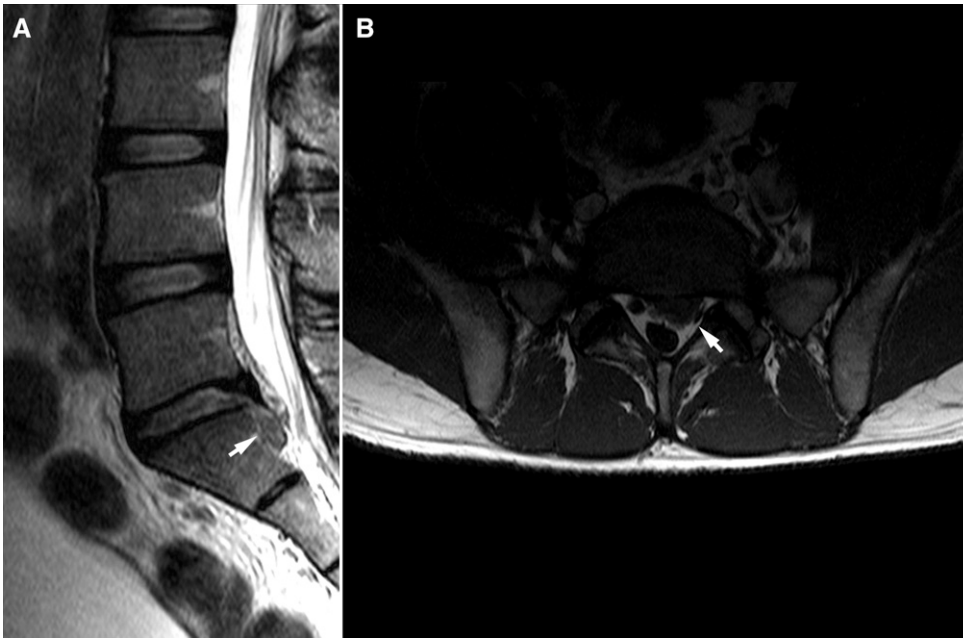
MRI result of a 33-yr-old man on the day of 8-G training. A) T2-weighted sagittal MRI, and B) T1-weighted axial MRI. The herniated disc was sequestered along the posterior surface of the S1 vertebral body (A) and the S1 nerve root was compressed (arrow).
